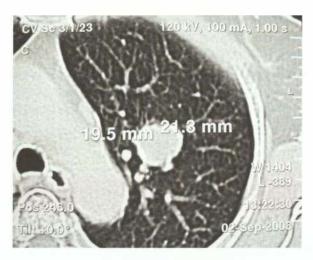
Lung metastasis in CT of the chest. It was not visible in X-ray chest
